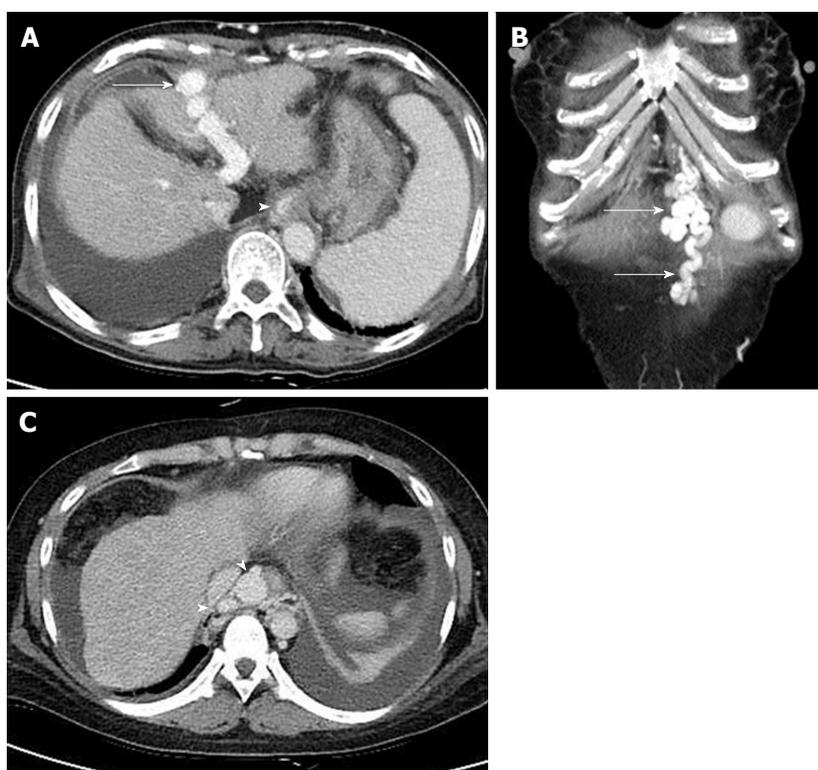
Image of liver cirrhosis caused by chronic hepatitis B. Contrast enhanced computed tomography portal phase images show multiple collateral vessels of portal vein. A: The image presents large intrahepatic portosystemic shunt through left portal vein and recanalized paraumbilical vein (arrow). Lower esophageal varix is seen (arrow head); B: Coronal image shows prominent paraumbilical veins (arrows); C: Axial image shows engorged paraesophageal varix (arrow heads) which usually supplied by left gastric vein and drained into azygos- or hemiazygos-vein.
